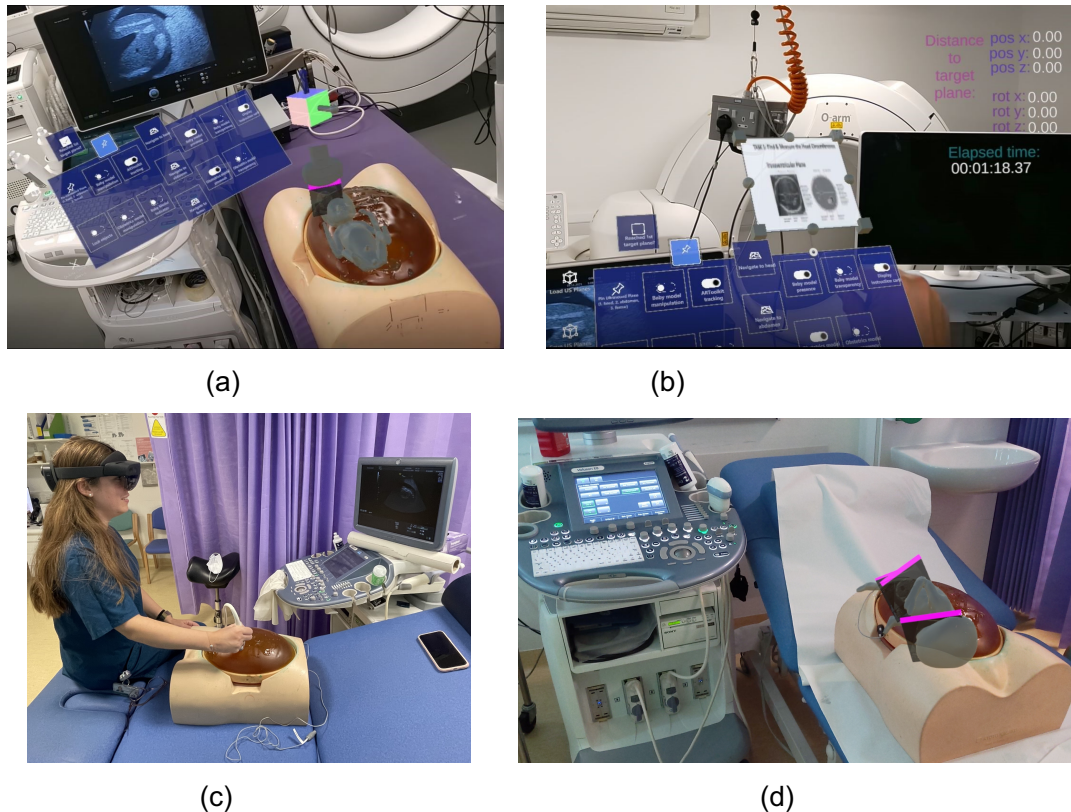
Views of the CAL-Tutor in use, as seen by the Hololens user: (a) An example target ultrasound plane has been set through the fetal head. The user control panel is also visible (b) An optional instruction card with guidance information and visual reference for the ideal plane. (c) CAL-Tutor in use in clinical environment. (d) View of the clinical set-up including views of the target planes, from the perspective of the HMD user.
